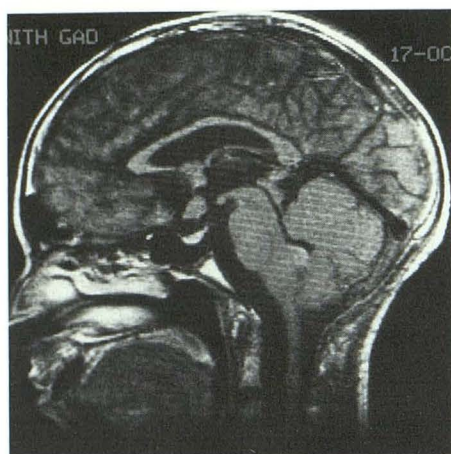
Case 4. Gd-enhanced MR image shows moderate enhancement of recurrent tumor in fourth ventricle, while metastases in the region of third ventricle fail to enhance.
